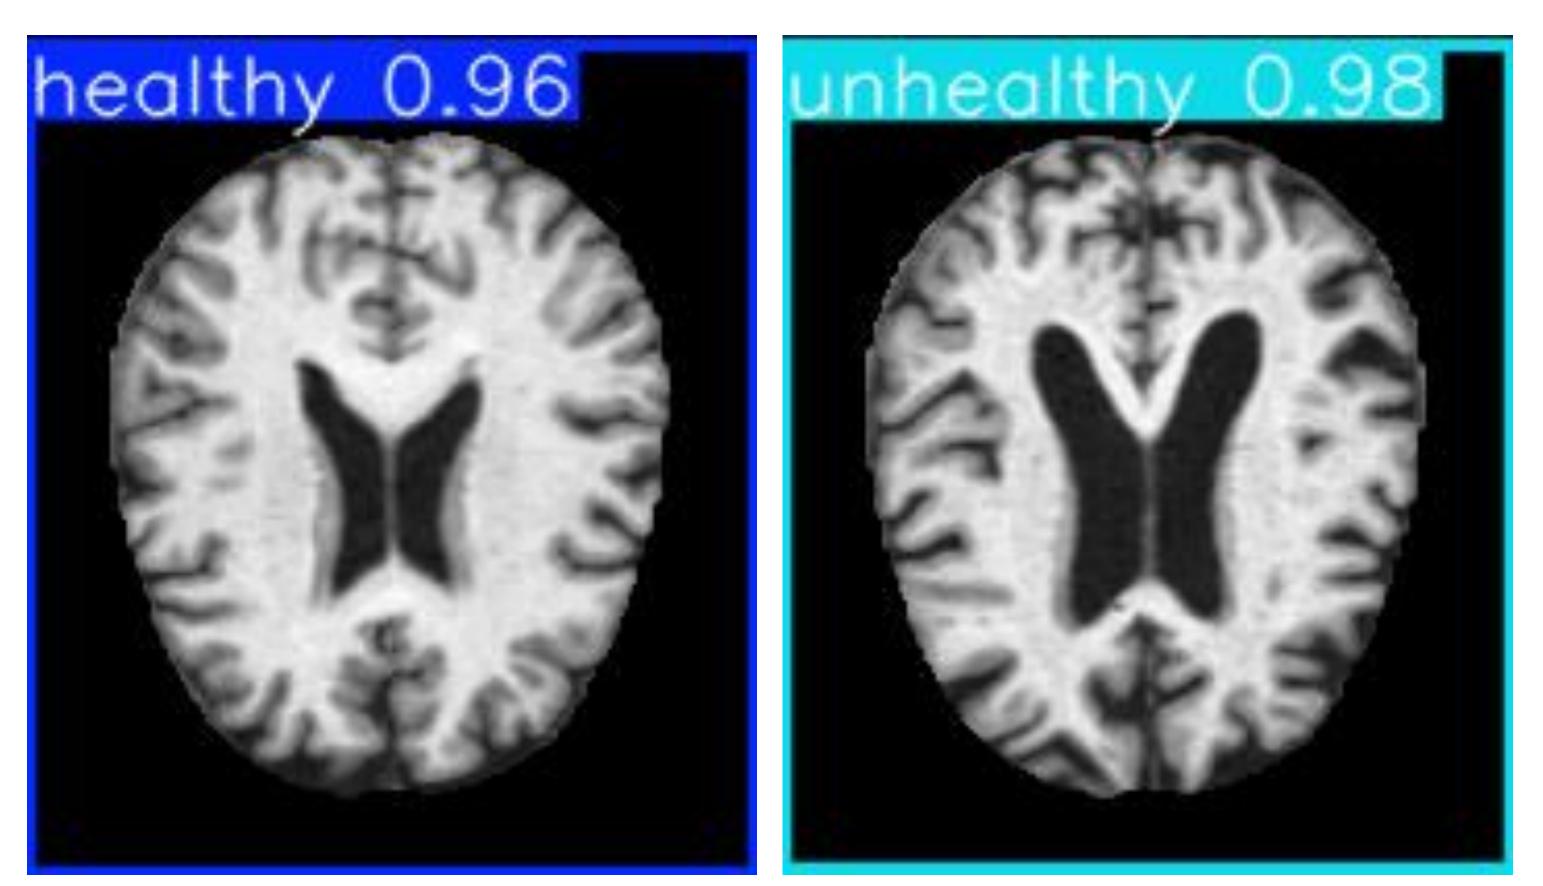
MRI Classification Examples: This figure shows two MRI images classified by the YOLO5 model. The image on the left is classified as "Healthy" with a confidence score of 0.96, while the image on the right is classified as "Unhealthy" with a confidence score of 0.98.
